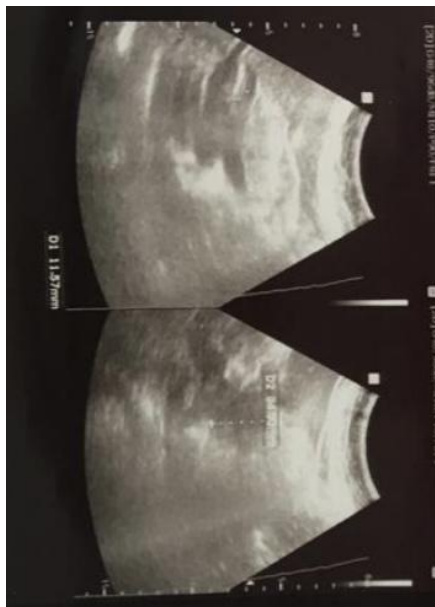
Abdominal ultrasonography revealing a heteroechoic in the pancreatic head, with common bile duct and biliary tract dilatation
